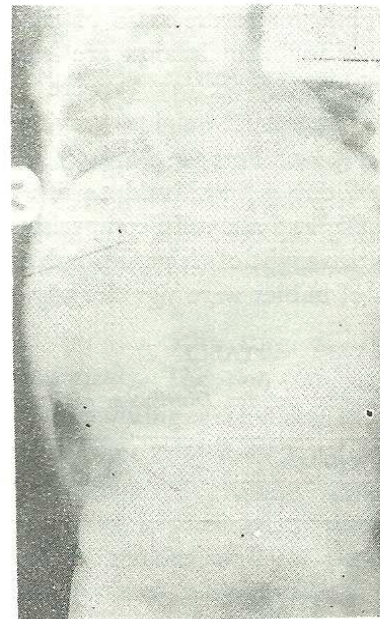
X-ray of chest and abdomen of a patient with exomphalos showing situs inversus and right-sided pneumonia
